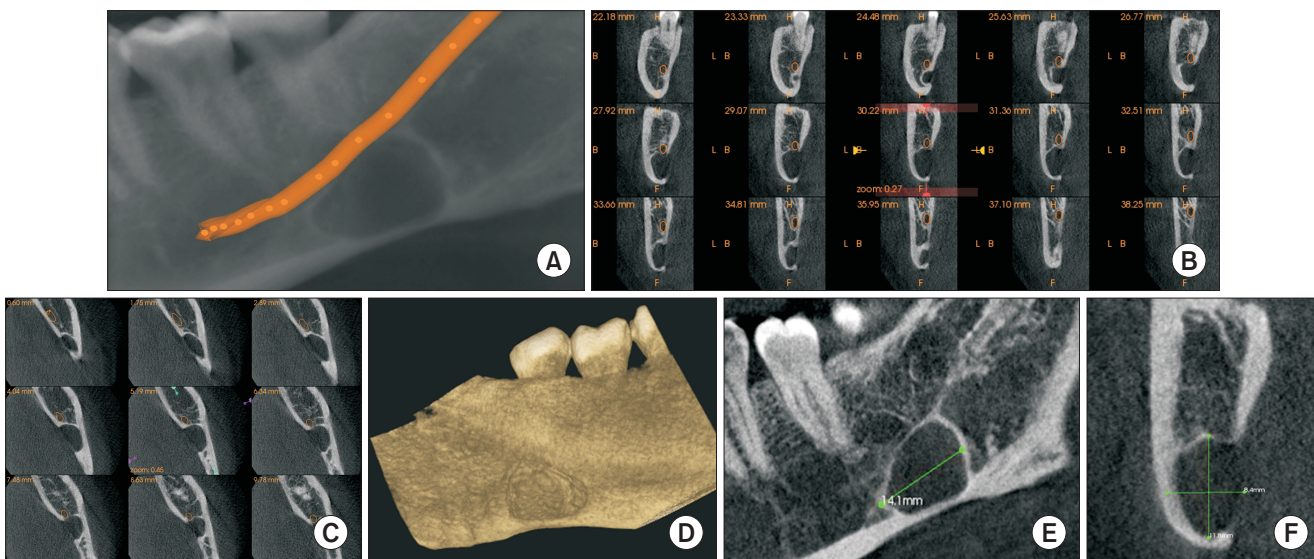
Cone-beam computed tomography images. A. Panoramic view with mandibular nerve canal traced. B. Cross-section revealing the relationship of the lesion with the mandibular canal. C. Axial view revealing the relationship of the lesion with the mandibular canal. D. Three-dimensional reconstructed view from lingual aspect. E, F. Dimensions of the lesion.
